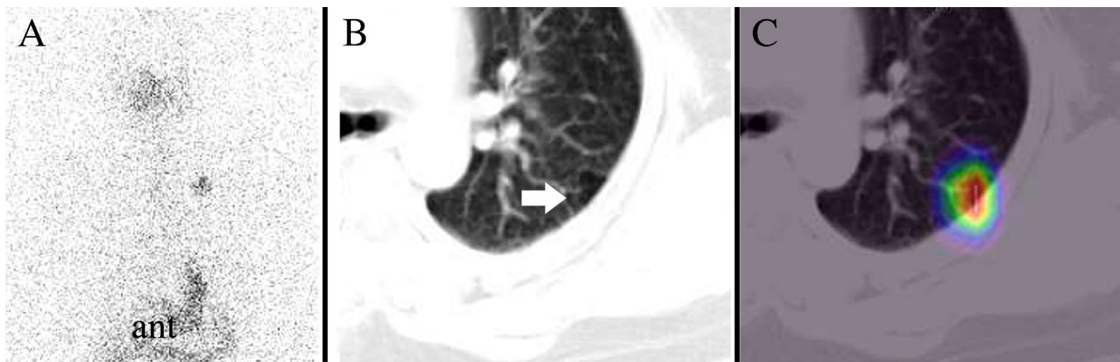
A patient with papillary thyroid cancer previously treated with radioactive iodine underwent diagnostic ^{131}I -radioiodine scan owing to raised serum thyroglobulin. The planar study (A) showed a focus of abnormal tracer accumulation in the left thoracic region, likely owing to lung metastasis. However, SPECT/CT localized tracer uptake within the left lung to a cavity, which is likely infectious. It also showed many nontracer-avid subcentimeter nodules in both lung fields suggestive of poorly differentiated lung metastases and revealed etiology of elevated serum thyroglobulin.
